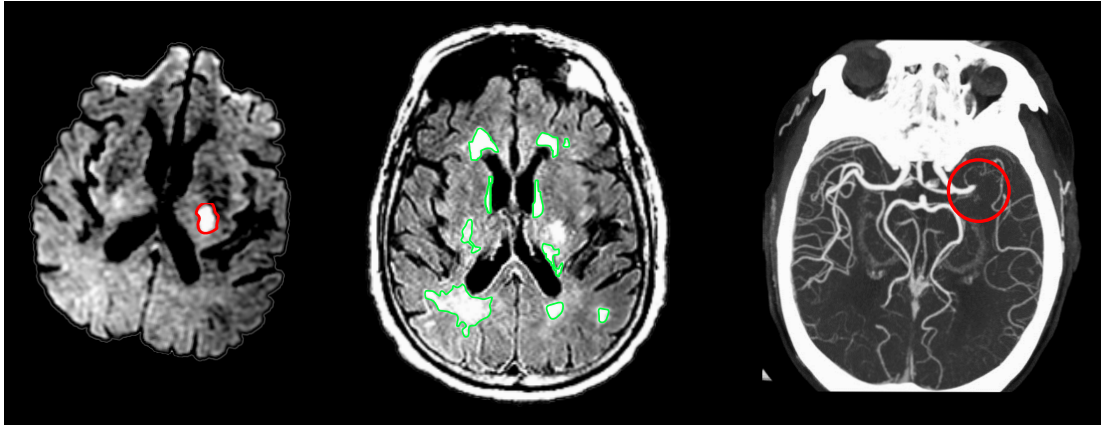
Example of imaging used in stroke patients. Diffusion weighted imaging (DWI, left) visualizes acute infarct (red outline), T2-FLAIR MRI (middle) shows the white matter hyperintensity, or *leukoaraiosis* (green), and computed tomography angiogram (CTA, right) captures the cerebrovascular tree and the blood flow stoppage.
